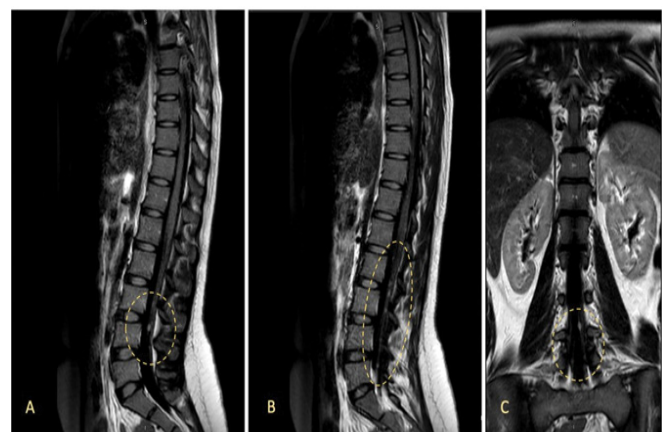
MRI study after one cycle of adjuvant chemotherapy, showing several millimetric nodular lesions with gadolinium contrast enhancement inside the dural sac and the roots of cauda equina, suggesting an early relapse of ES with meningeal carcinomatosis. Sagittal vision (A, B) and coronal vision (C) with a fluid attenuated inversion recovery (FLAIR) sequence.
